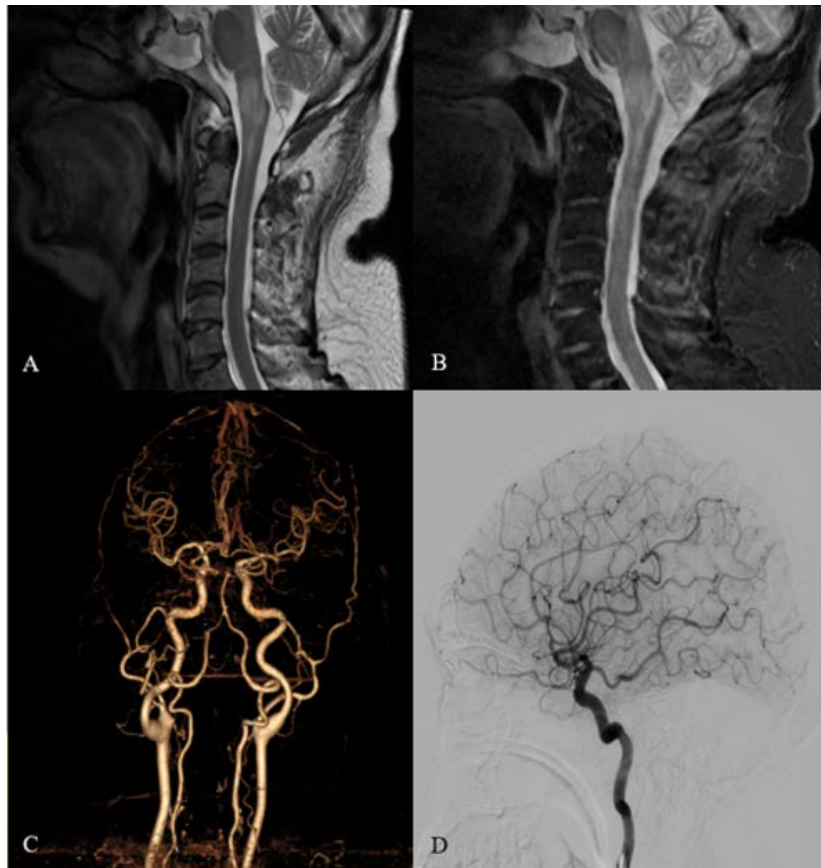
A 62-year-old male patient with Cognard type V dAVF: Postoperative imaging. (A), (B): Sagittal T2-weighted and STIR images of the cervical spine demonstrate marked reduction of spinal cord edema and absence of anterior perimedullary flow voids. (C): Three-dimensional CTA showing no residual vascular malformation. (D): Follow-up DSA confirming complete obliteration of the fistula.
